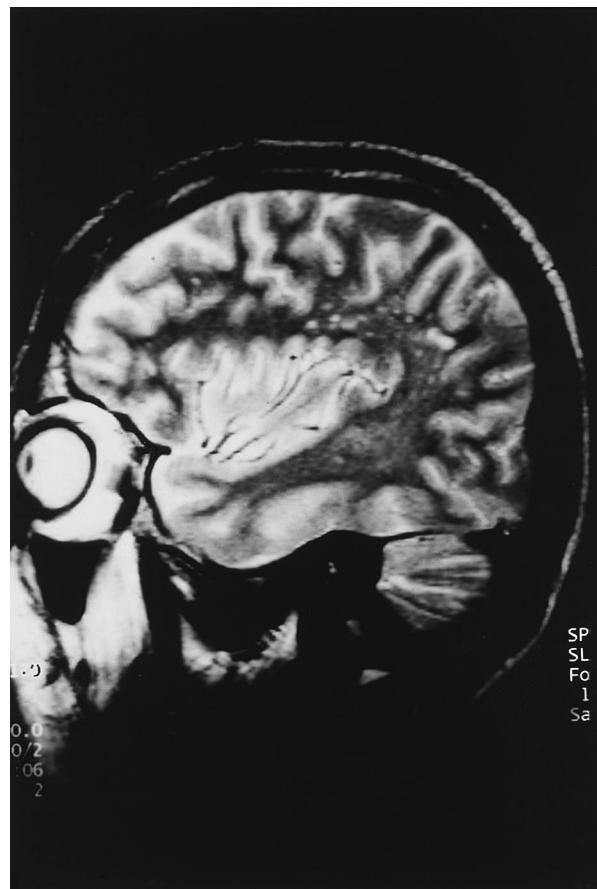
weighted and proton density-weighted magnetic resonance imaging scan showing bilateral high-signal areas in parieto-occipital subcortical white matter.
